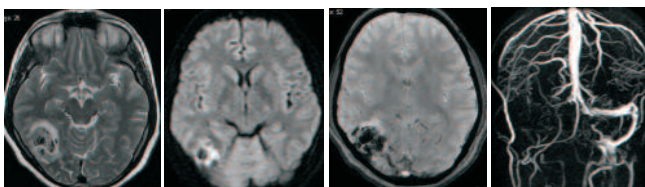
a) T2WI Axial b) DWI Axial c) SWAN Axial d) Venography
